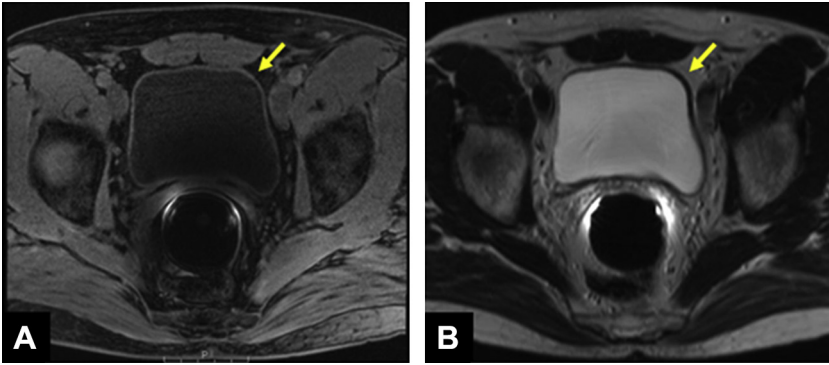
Normal urinary bladder. (A) Axial T1-weighted image shows intermediate signal intensity of urinary bladder wall (*arrow*). (B) Axial T2-weighted image shows low signal intensity of urinary bladder wall (*arrow*).
